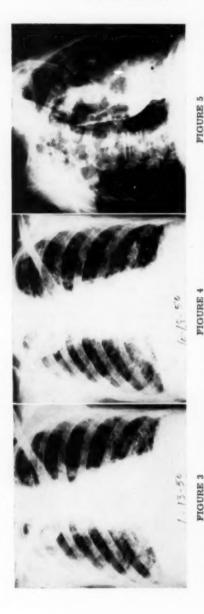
Appearance of chest roentgenogram on admission. Note the diffuse reticular and net-like shadows, lower two-thirds of both lung fields. The increased density of the right upper lung field results from old injury in which there were multiple fractures of clavicle and first rib.—Figure 4: Appearance of chest roentgenogram after one month course of para-aminobenzoic acid. There is no essential change...Figure 5: Roentgenogram of esophagus showing narrowing in the lower two inches with dilatation above.
